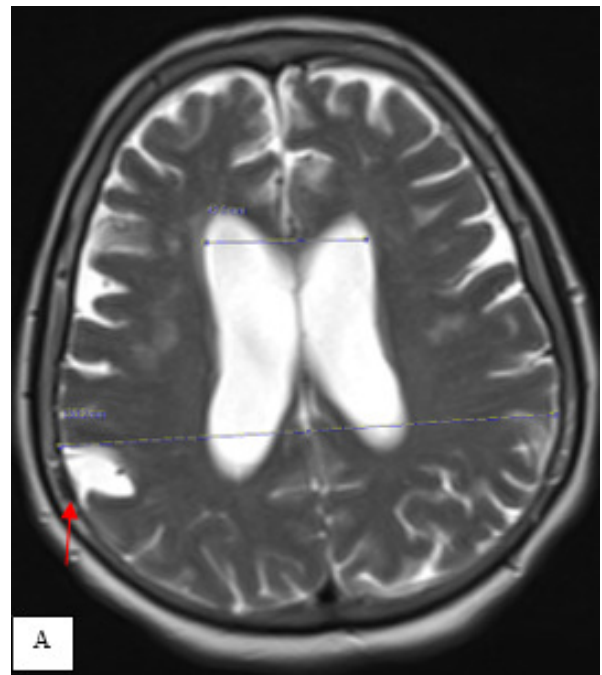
(A, B) Axial Bone window images of the head CT demonstrating dilated diploic veins throughout the cranium, more prominent at the right side (A, red arrow). An intraosseous AG is shown (B, white arrows).C,D) Axial T2w MRI showing the CSF signal intensity within the same DV (C, red arrow) and another intraosseous AG projecting into the occipital bone with characteristic CSF signal on T2w images (D, white arrow)
